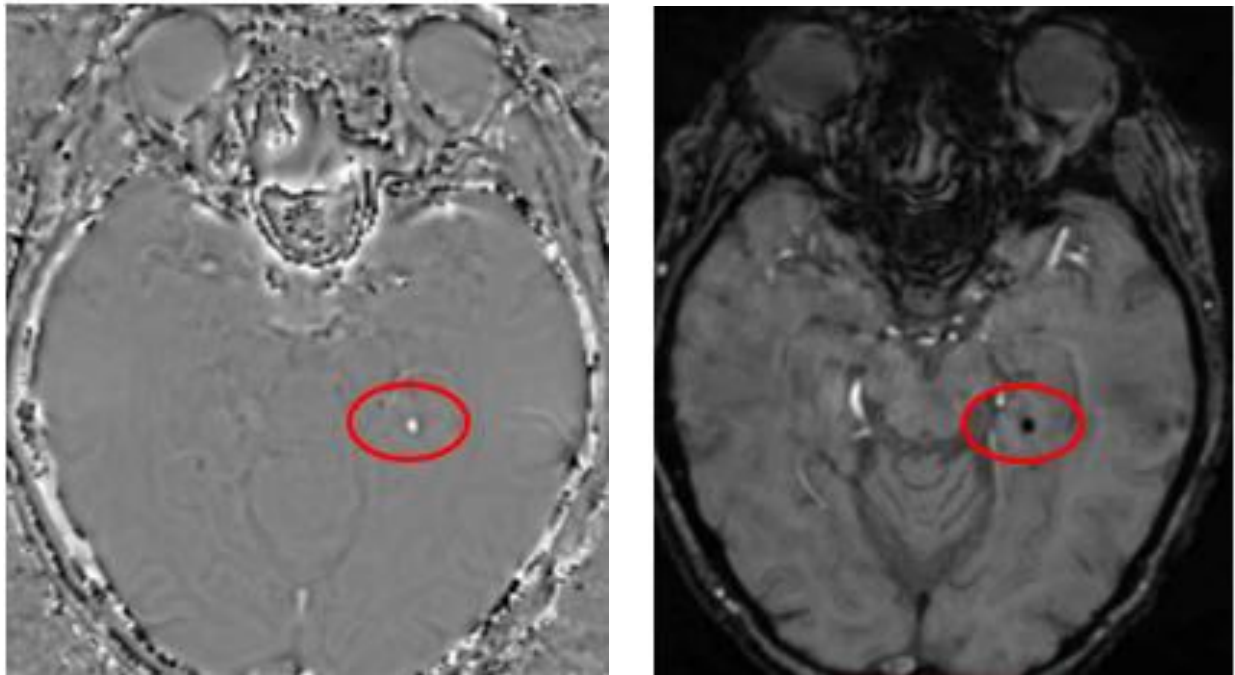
A case of MRI-defined CMB. Lt. single CMB in the hippocampal region presents small and round hypointense foci on the sensitive T2-weighted gradient-recalled echo (GRE) or susceptibility-weighted sequences (SWI).
